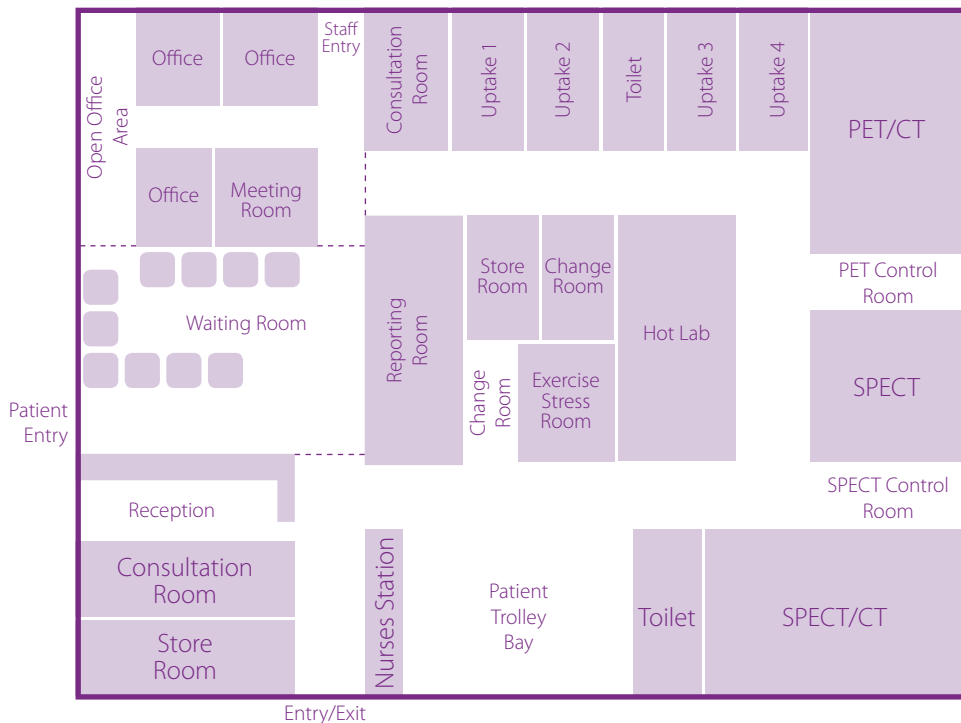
A sample floorplan for a larger department that includes two gamma cameras, both a SPECT and SPECT/CT, and a PET/CT. The addition of a meeting room/library can be used for continuing education of the staff and allows additional space for both internal and external clinical and non-clinical meetings
